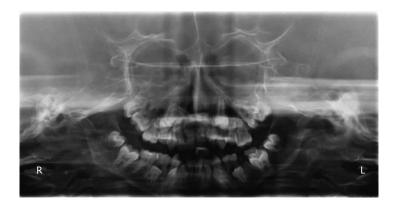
Panoramic radiograph showing delayed eruption of the permanent teeth, hypodontia of the left upper second premolar and both lower second premolars, and temporomandibular joint malformation.
